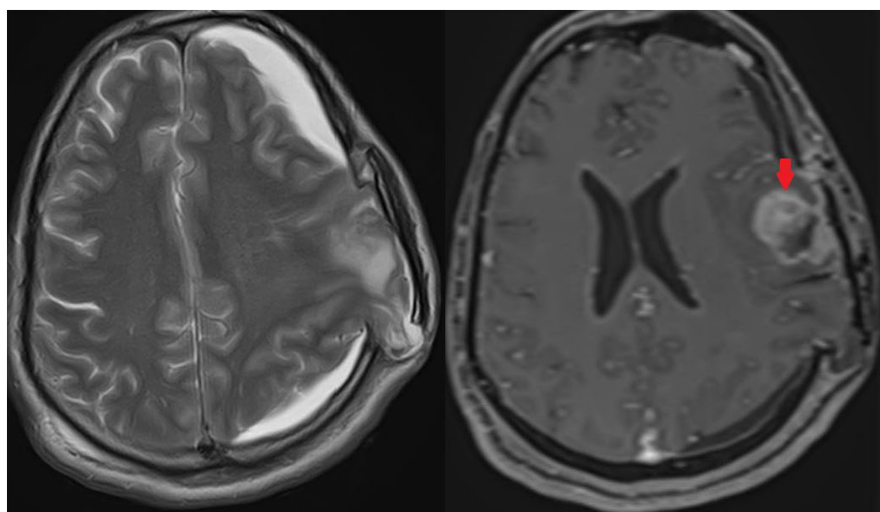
T1 and T2 section of magnetic resonance imaging (MRI) showing residual tumor in left inferior frontal gyrus (red arrow).
